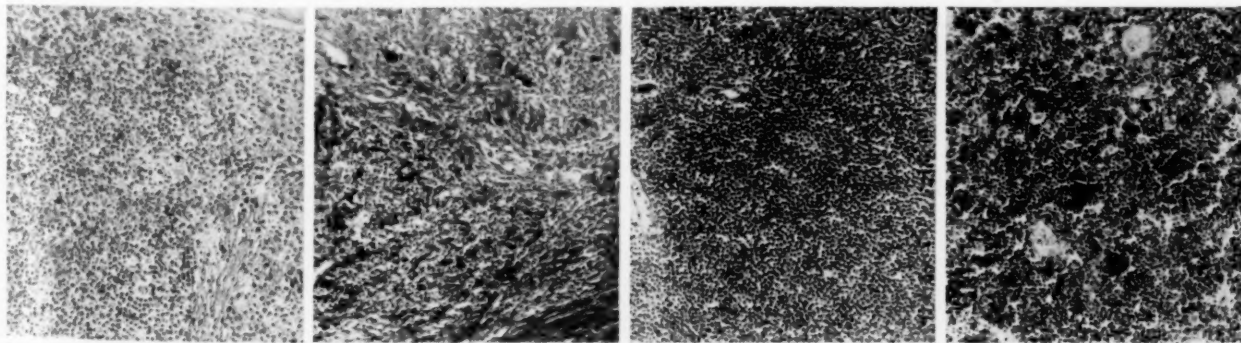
Case III—A. P. No. 556: First adenectomy. Active Hodgkin's disease of two years standing with fine diffuse fibrosis and moderate eosinophilia. Had a few x-ray exposures several months before this gland was excised.
